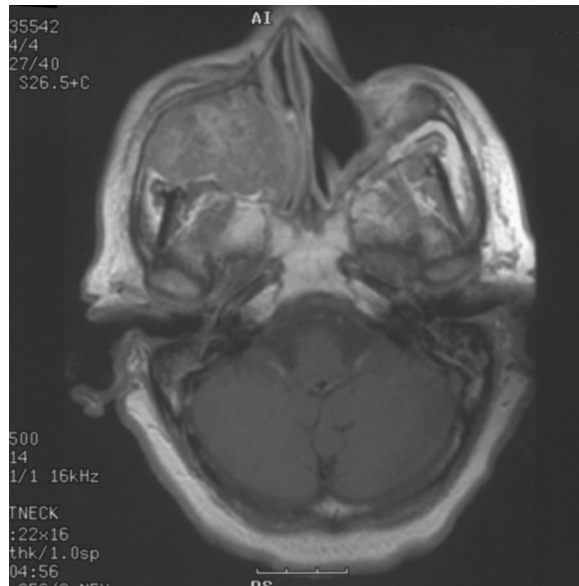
Same patient as in Fig. 9. MRI T1W post-gadolinium of adenocarcinoma showing heterogeneous enhancement of tumour throughout the right sinonasal cavity and maxillary sinus.
